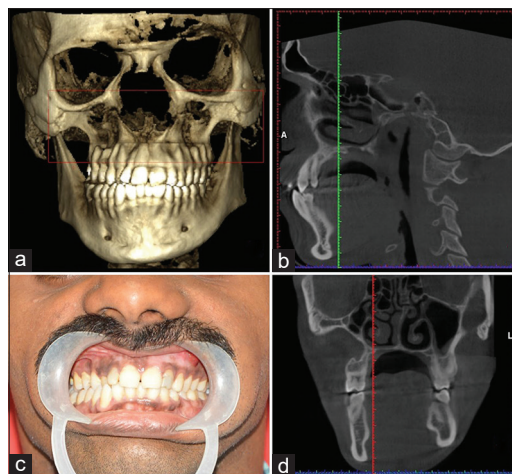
(a-d) Computed tomography images and occlusion of the patient
